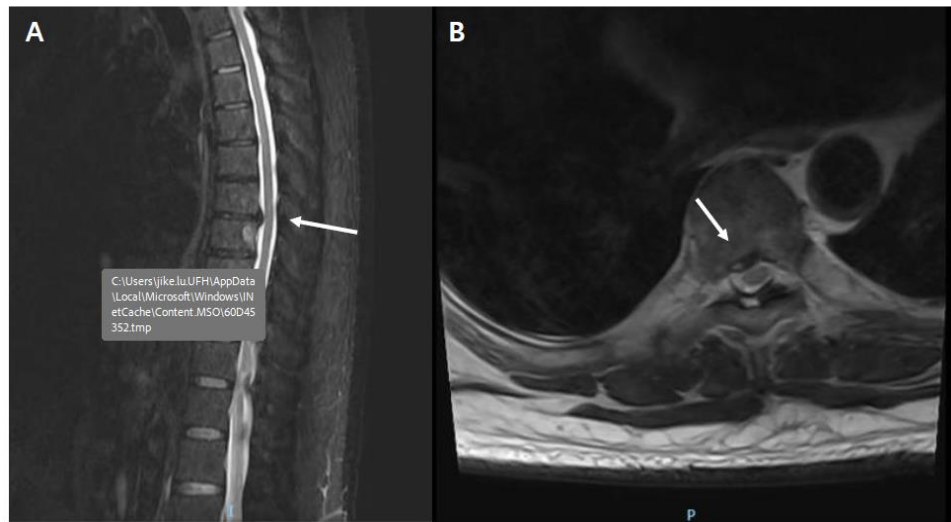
MRI showed disc prolapse (arrows) at level of T6-7 on the right which was irrelative his left side clinical symptoms.
